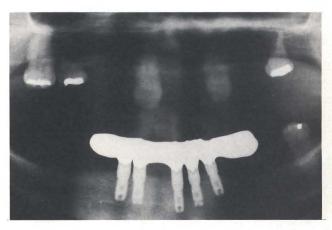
Radiograph with the five implants and the bridge in situ.
